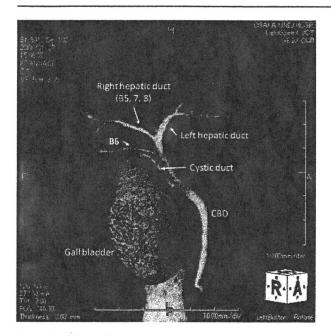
Three-dimensional reconstruction view of the drip infusion cholangiography computed tomography scan. The donor B6 bile duct rose from the common hepatic duct separately from the right hepatic duct (B5, B7, and B8).
